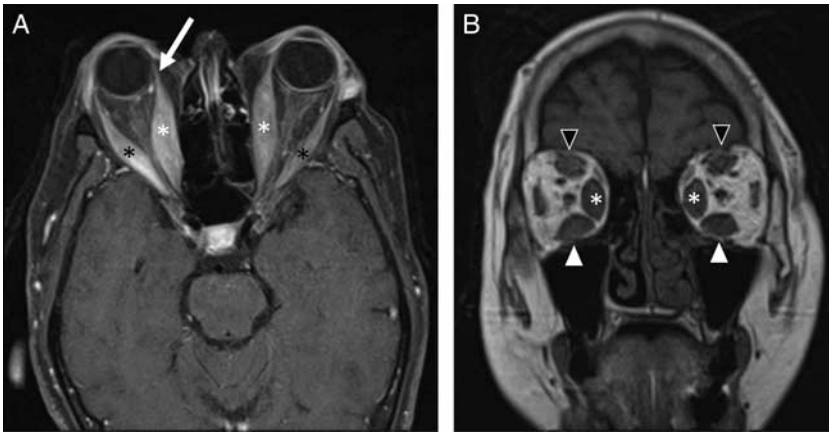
59-year-old woman with a history of Graves disease presented to the emergency department with acute onset of bilateral eye swelling and diplopia. Axial (A) T1-weighted postcontrast fat-saturated MRI demonstrates abnormal thickening and enhancement of the right greater than left medial (white asterisks) and lateral rectus muscles (black asterisks) with sparing of the tendinous insertion (white arrow). Coronal (B) T2-weighted shows enlargements of the bilateral superior rectus (black arrow heads), medial rectus (white asterisks), and inferior rectus muscles (white arrow heads).
